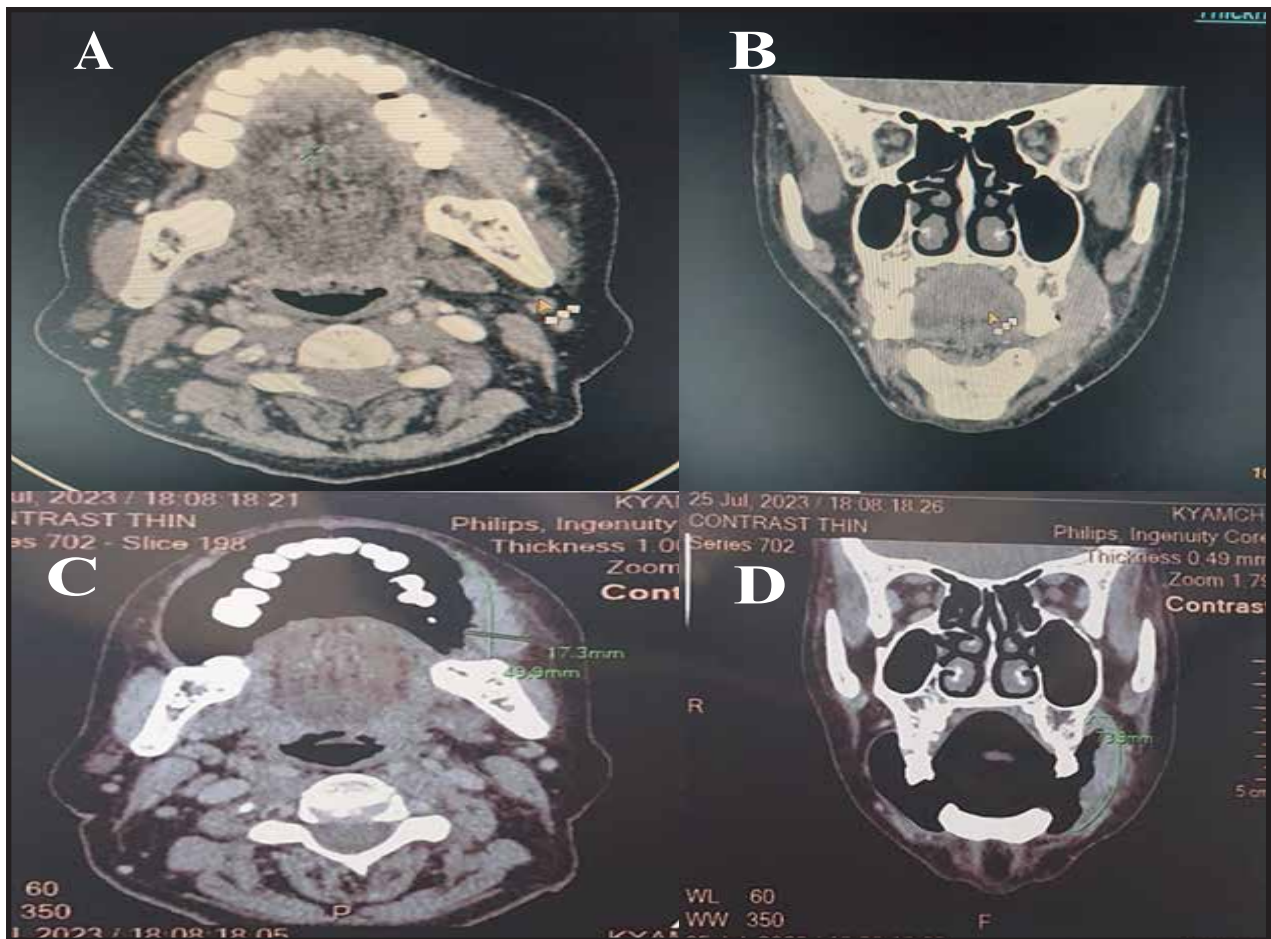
61-year-old man with invasive squamous cell carcinoma of the left buccal mucosa. (a, b) Conventional axial, coronal CT scan through the occlusal plane shows enhancing thickening along left buccal mucosa. (c, d) Puffed-cheek axial, coronal CT scan shows an enhancing soft tissue lesion on the left buccal mucosa. The buccal mucosa and buccinator muscle together, infiltrating superior gingiva-buccal sulcus.
